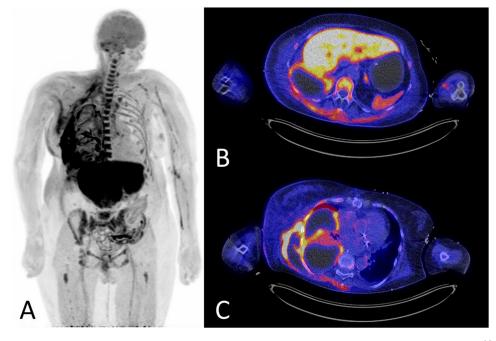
A sedated and intubated 75-year-old patient suffering from sepsis of unknown origin was referred for ¹⁸F-FDG-PET/CT. The maximum intensity projection visualizes a severe and extensive infection and inflammation (A). Remarkable is the high ¹⁸F-FDG uptake in the liver, which might have been caused by acute liver failure (B). Most important for the clinical presentation is the extensive fluid collections in the right hemithorax, extending to the thoracic wall with intense ¹⁸F-FDG uptake on the edges and at the level of interlobular septa (C). There is also induration in the surrounding soft tissues. These findings are most consistent with extensive thoracic empyema. Biograph Vision Quadra (Siemens Healthineers, Erlangen, Germany), axial field-of-view 106 cm, scan-time of 3 minutes in one bed position.
